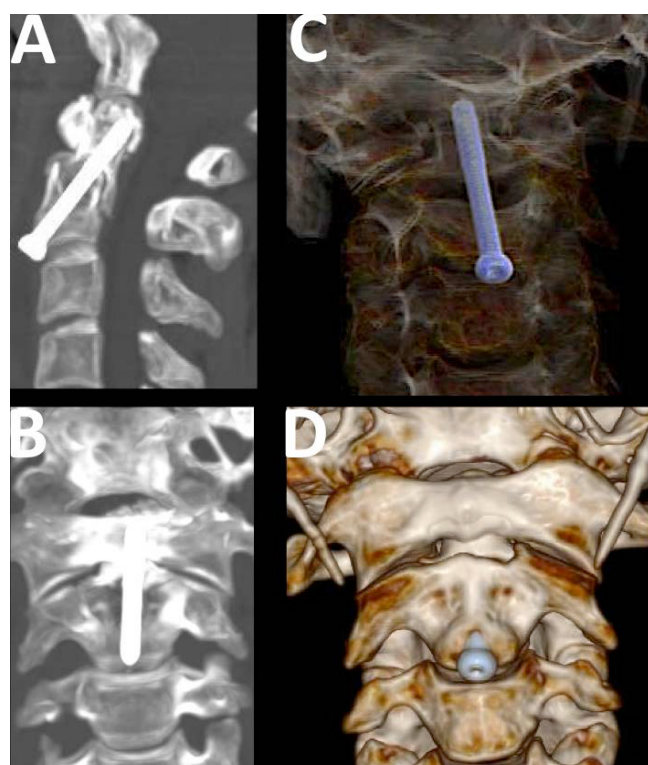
(A, B) Sagittal reconstructed CT scan showing adequate placement of the odontoid screw. (C, D) 3D-sagittal reconstruction view 90 days after the operation.
